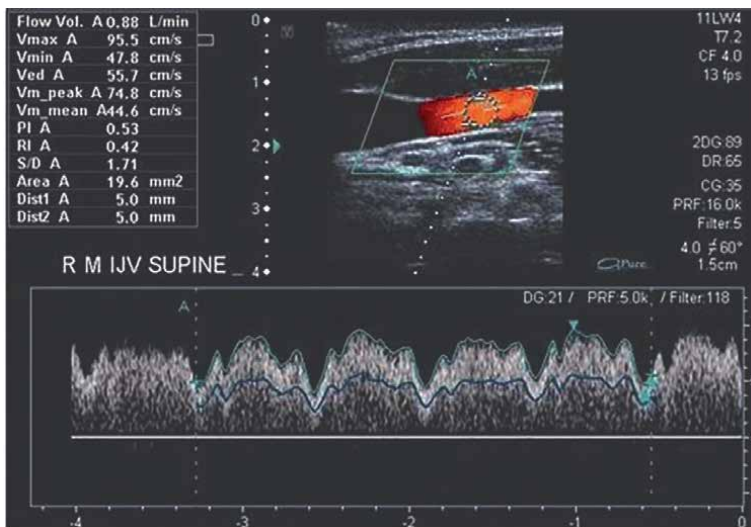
Duplex ultrasound image with color doppler demonstrating measurement of BVF in the J2 segment of an IJV by calculating the circular CSA of the vein with BVF averaged over 3–5 cardiac cycles in the supine position. The BVF measurement obtained from the J2 segment IJV shows an abnormally high-flow rate of 880 ml/min [14].
